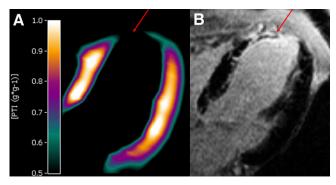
Parametric PTI_{Vb} image obtained using PET/CT scanner (A) and corresponding DCE MR image (B) of typical patient with myocardial infarction, indicated by reduced PTI_{Vb} and hyperenhancement in DCE MR image. Arrows indicate myocardial infarction.
